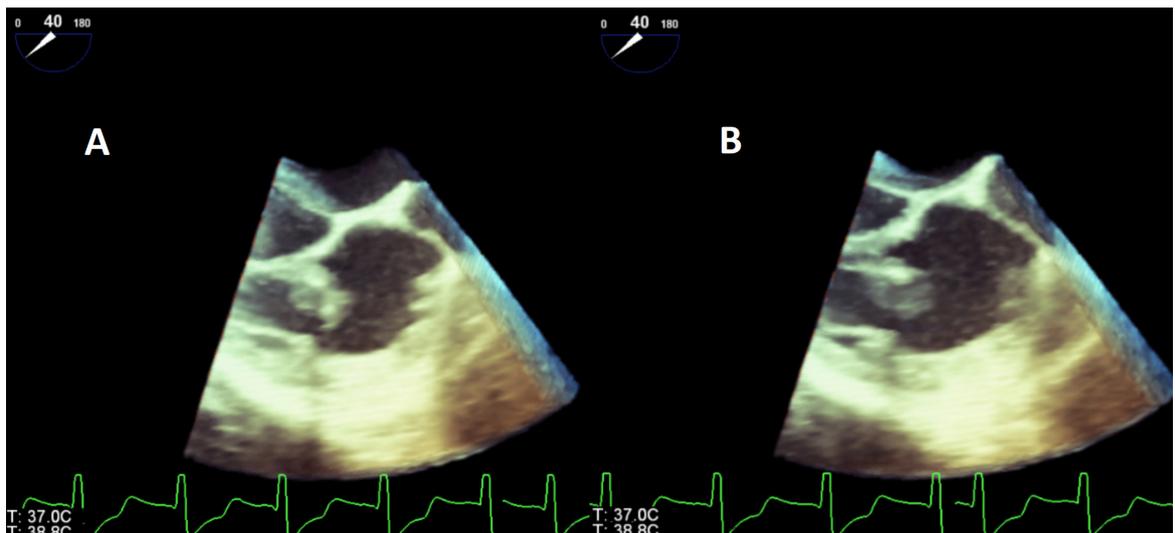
(A–B) Transesophageal echocardiogram at mid-esophagus showing different still-frame 3D-images of vegetation prolapsing in and out of the right ventricle. (A) Vegetation prolapsing in and out the right ventricle. (B) Tricuspid valve vegetation prolapsing in and out the right ventricle.
